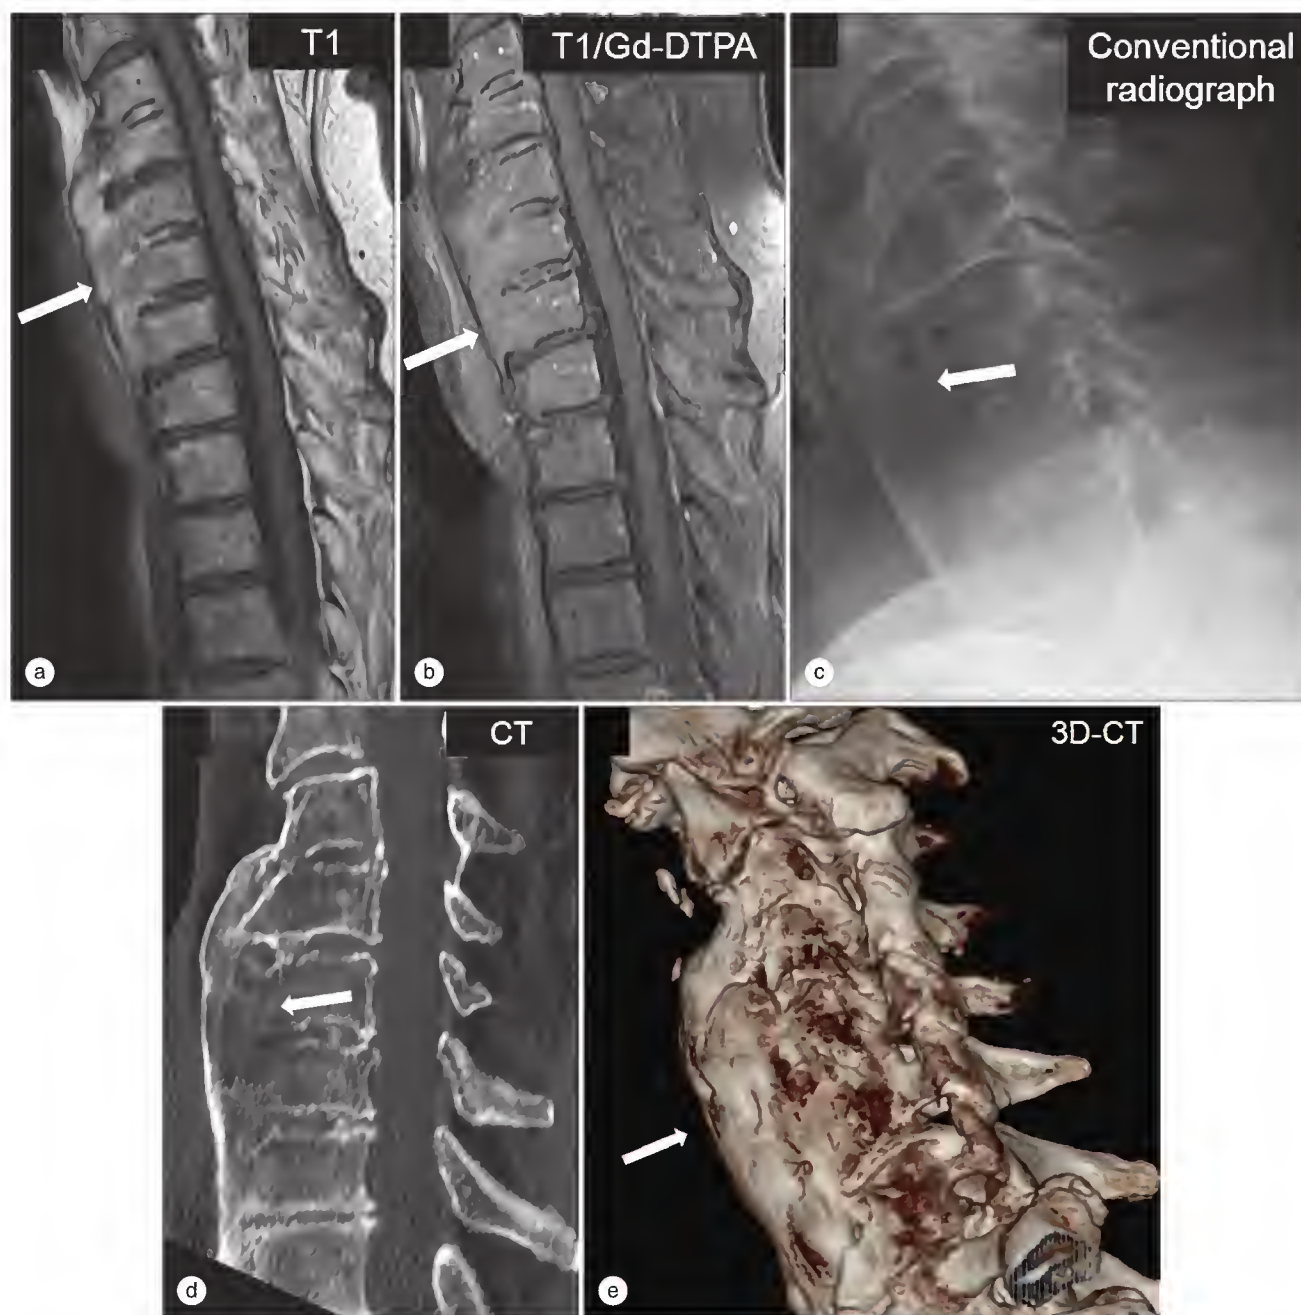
Diffuse idiopathic skeletal hyperostosis (DISH) in the cervical spine as imaged by magnetic resonance imaging (a, b), conventional radiography (c), and computed tomography (d, e). DISH is characterized by bulky osteophytes that exceed the length of the anterior longitudinal ligament.
